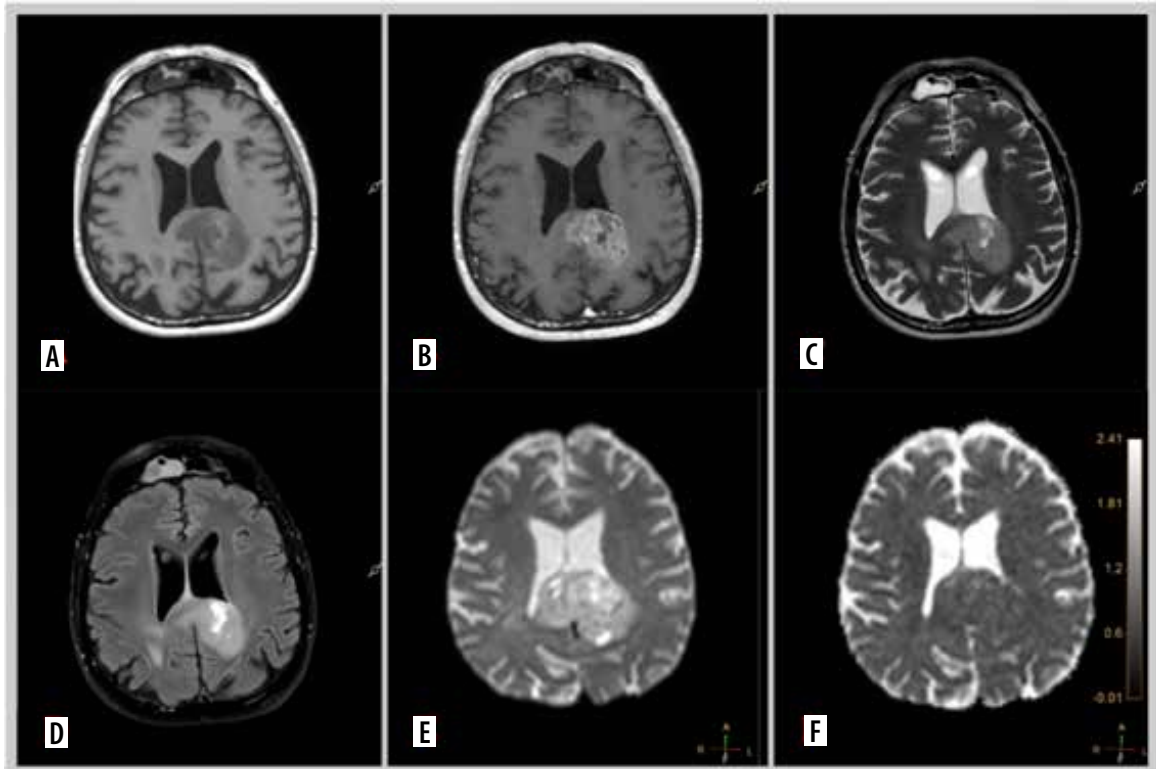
Representative magnetic resonance images of examined patient. A 68-year-old man with glioblastoma G4. Molecular characteristics: *IDH1*-wild-type, present *TERT* promoter pathogenic variant, *CDKN2A* homozygous deletion, *EGFR* amplification, *MGMT* promoter unmethylated. A) Pre-contrast T1. B) Contrast enhanced tumour on T1 post gadolinium. C) T2-weighted scan. D) Fluid-attenuated inversion recovery (FLAIR). E) Diffusion-weighted imaging (DWI). F) Reduced diffusion on apparent diffusion coefficient (ADC) map
